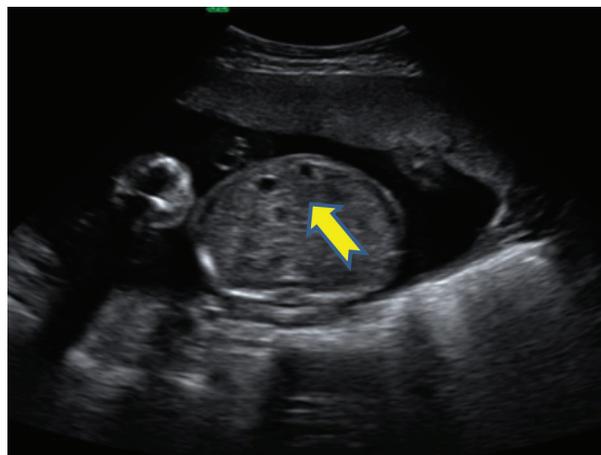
Ultrasound examination revealed a cystic structure with minimal intestinal dilatation at the umbilical cord entry level of the fetal abdomen
